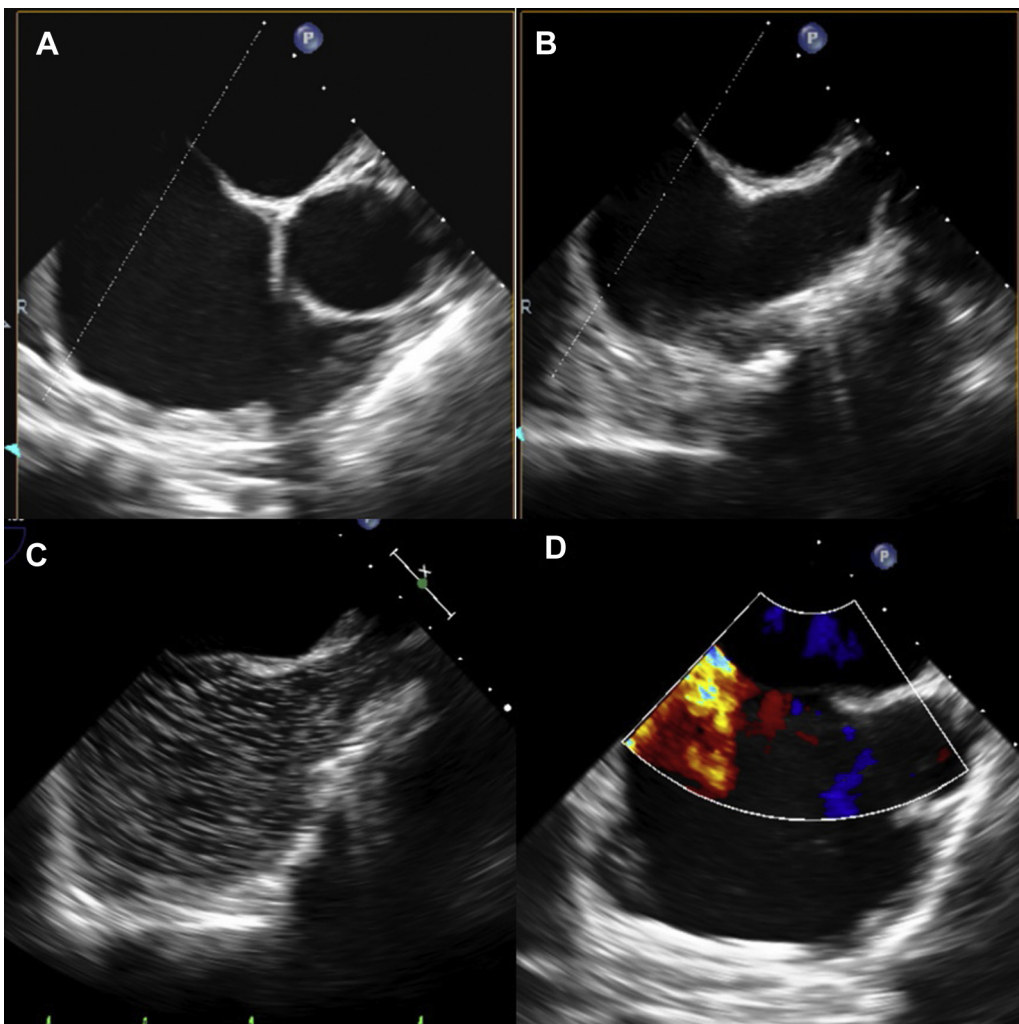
Baseline transesophageal echocardiogram from case 1 demonstrates an intact interatrial septum by 2-dimensional (A, B), agitated saline (C), and color imaging (D).
